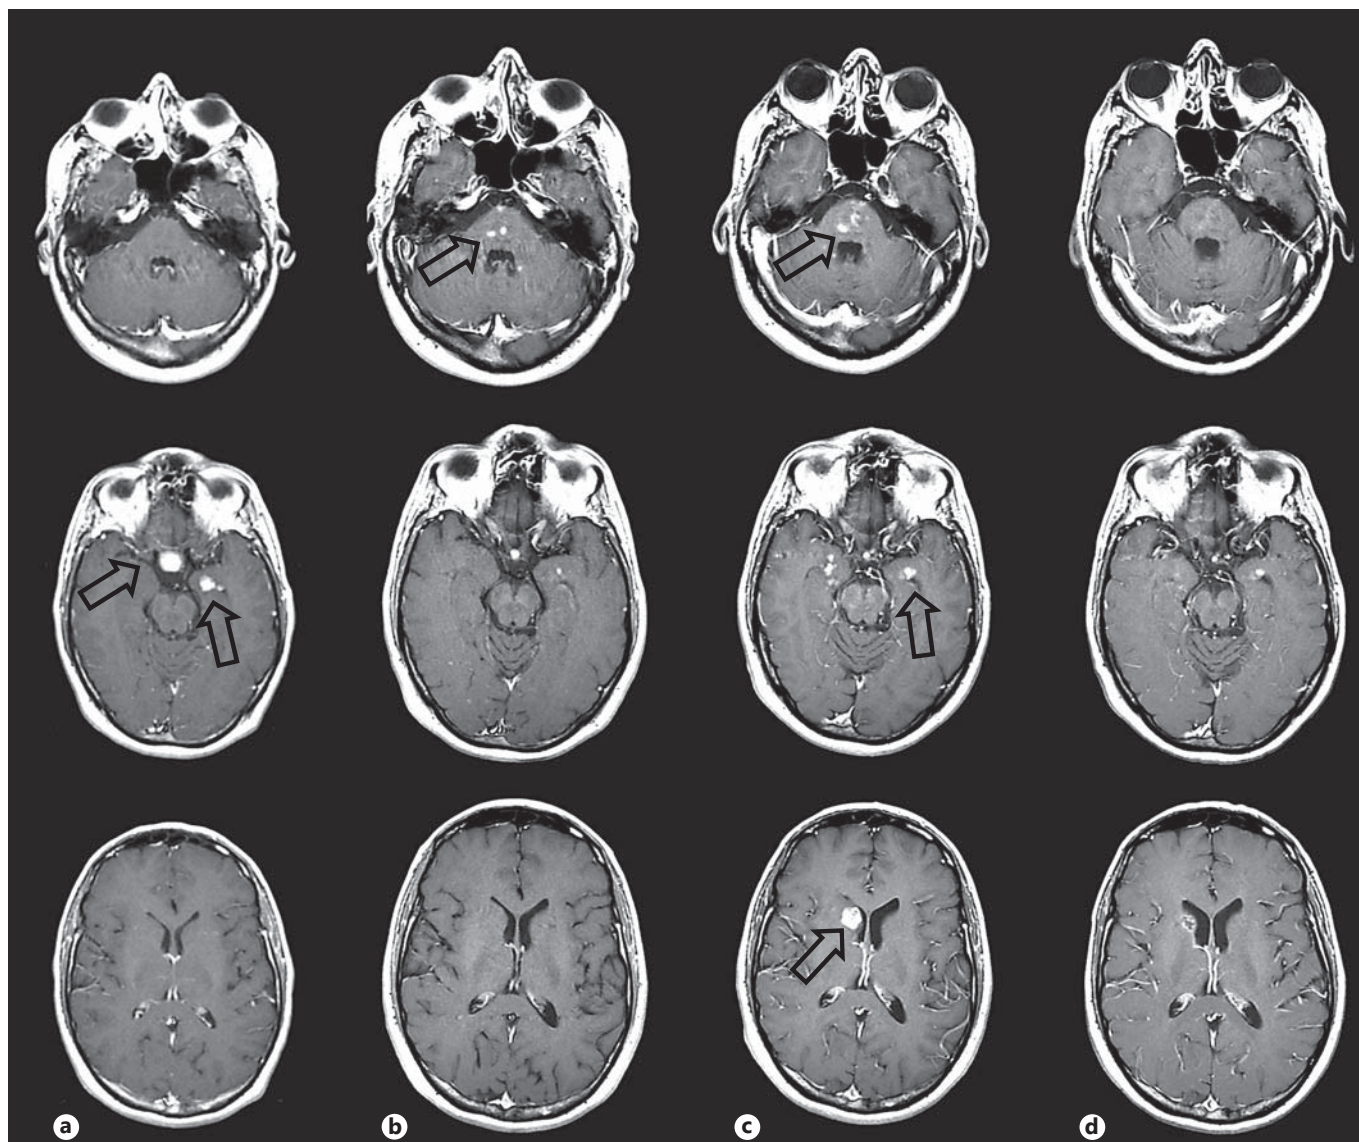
Contrast-enhanced axial T1-weighted MRI images showing the brainstem at the pons level (upper row), pituitary and medial temporal lobes (middle row), and at the level of the head of the caudate nucleus. These images are arranged in columns by time sequence: at the time of diagnosis (a); 2 years after diagnosis (b); 4 years after diagnosis and just before treatment (c); 7 months after treatment (d). a Heterogeneous contrast-enhancing lesion in the sellar region and the left medial temporal lobe (arrows). No pontine and caudate nucleus lesions are seen. b The sellar and medial
